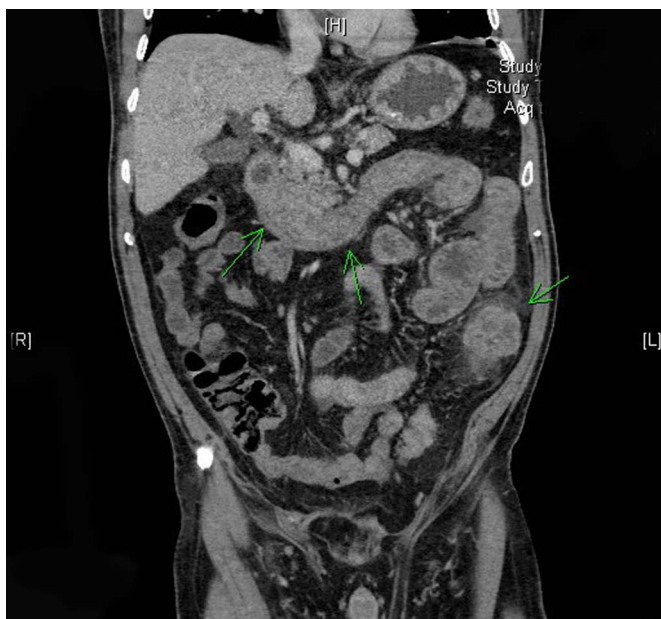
Coronal abdominal computed tomography with contrast shows moderate thickening of the small bowel and marked thickening of the duodenum and proximal jejunum.
